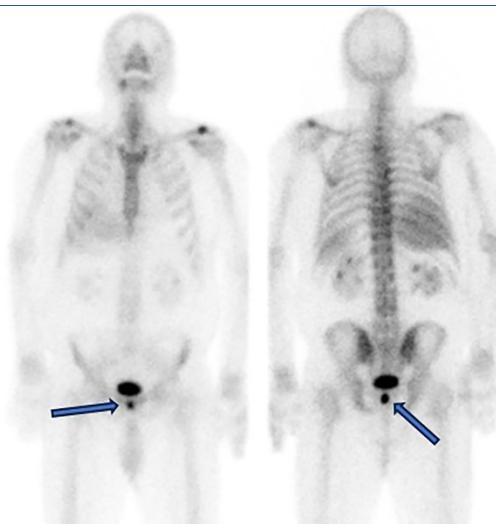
The anterior and posterior planar images demonstrated increased radiotracer uptake in the pubic region, located just beneath the urinary bladder. The more prominent uptake observed in the posterior view suggests a lower probability of metastatic involvement of the pubic bone; therefore, additional SPECT/CT imaging has been scheduled for the patient
